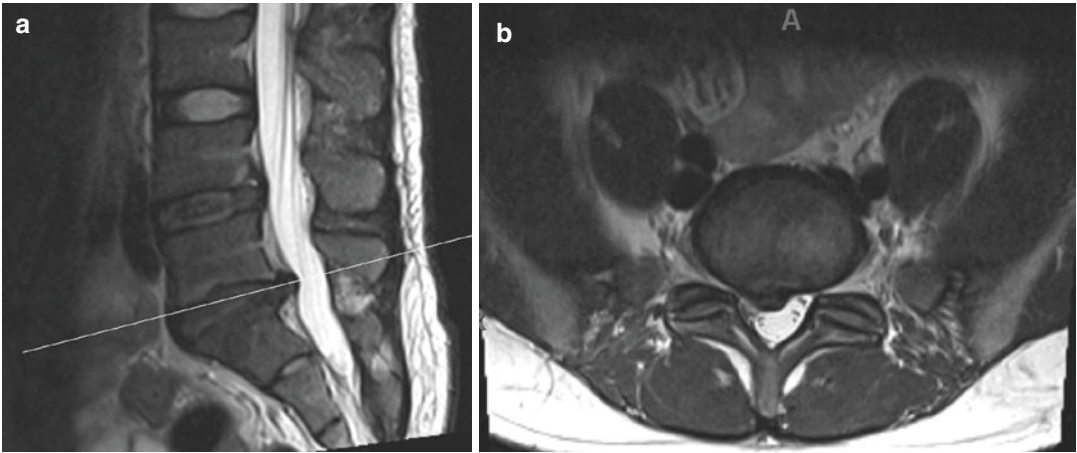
Routine spinal imaging should include an axial T2-weighted sequence oriented to the disc spaces to improve evaluation of disc disease. The sagittal sequence
